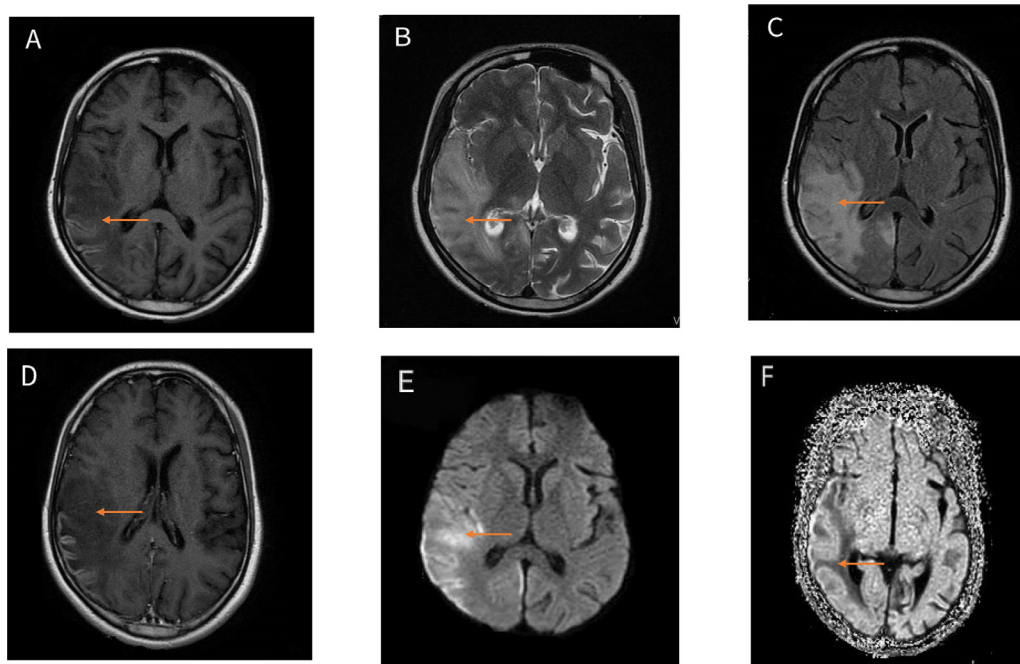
There is mild left cerebral atrophy (A–E). Gyrform restricted diffusion is observed in the right temporo-parieto-occipital cortex, (arrows) on axial DWI (E). Associated gyral swelling. Hypointense signal (arrows) is seen on T1WI (A), hyperintense signal on axial T2W (B) and FLAIR (C). No enhancement is seen in this region on post-contrast axial T1W image (D). There is low signal on ADC (F).
